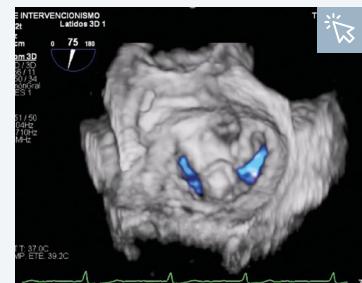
Final result on three-dimensional echocardiogram.²⁷
